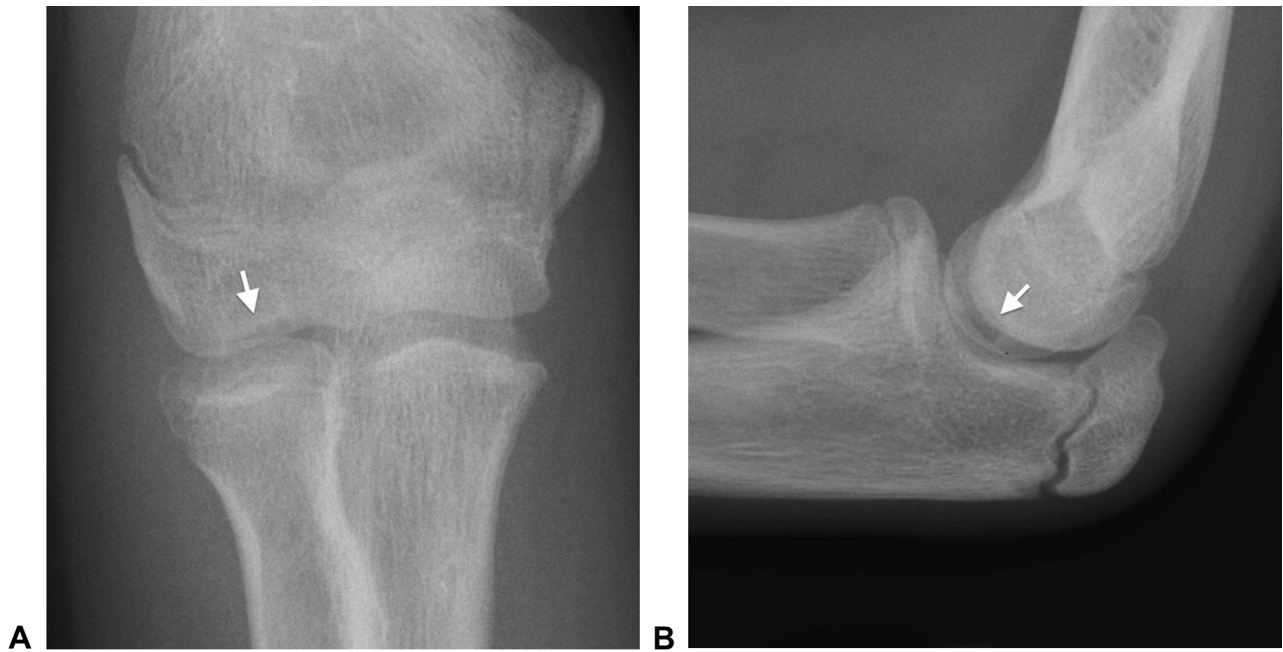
A Anteroposterior and B lateral radiographs demonstrate a focal radiolucency at the capitellum (white arrows) consistent with an osteochondritis dissecans lesion with bone loss. (Courtesy of Shriners Hospital for Children—Philadelphia.)
